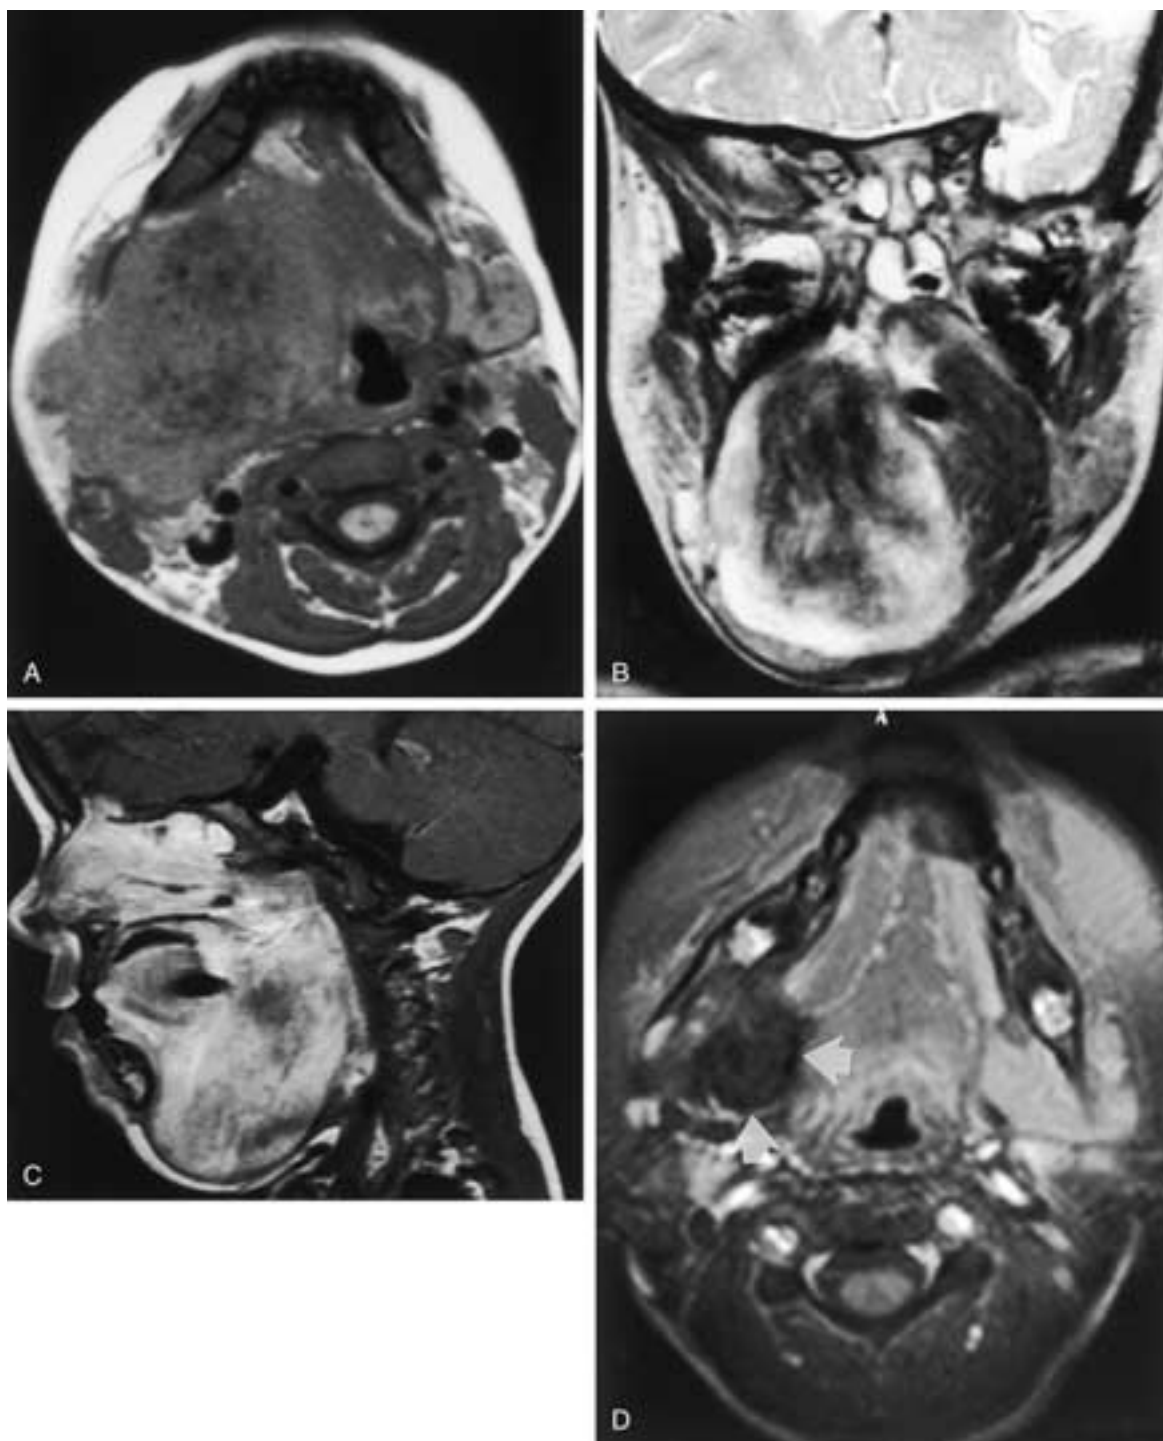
Aggressive fibromatosis. (A) Axial T1-weighted MR image demonstrates more heterogeneity in this lesion than that seen in [Figure 27-62](#), reflecting its dense fibrous content. This is impressive on the coronal T2-weighted image (B), as a significant portion of the lesion is markedly hypointense. T1-weighted image after contrast enhancement in the sagittal plane (C) demonstrates very heterogeneous enhancement. The true craniocaudal extent of the lesion is best appreciated on the sagittal image (C), which demonstrates involvement up to the skull base. Imaging 3 years later (after extensive treatment) with contrast-enhanced, fat-suppressed, T1-weighted imaging in the axial (D) plane reveals a remarkable decrease in the size of the lesion, with only an area of residual dense fibrous tissue remaining (*arrows*).
